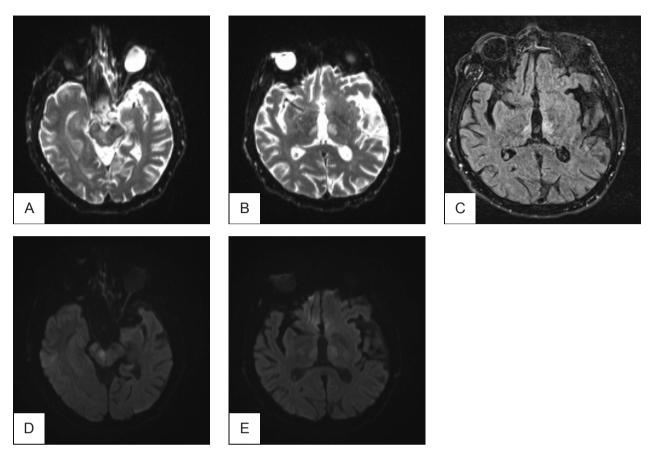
B.Z., axial ADC mapping (panel A-B), FLAIR (panel C) and DWI MRI (panel D-E) showing bilateral thalamic ischemia with the involvement of the right cerebral peduncle, on day 11 of onset.
